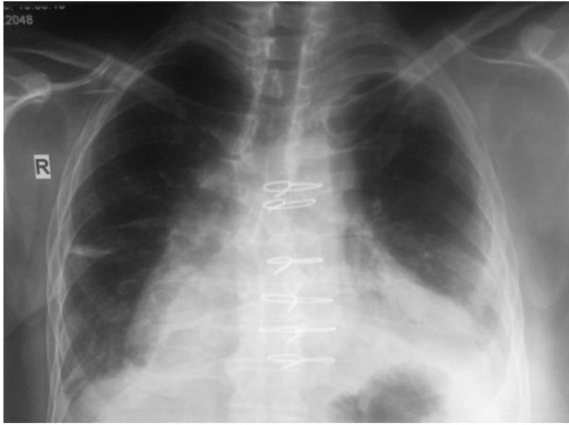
Postoperative chest X-ray showing expanded left lung.
